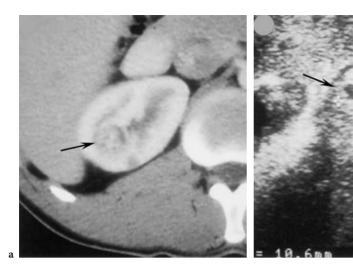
Solid renal mass. a Preoperative axial contrast-enhanced CT scan demonstrates a poorly defined mass (*arrow*) deep in surface of right kidney. b Intraoperative US image reveal 1-cm solid lesion (*arrows*) with small cystic components. Small lesion seen on CT on renal surface was fulgurated.
